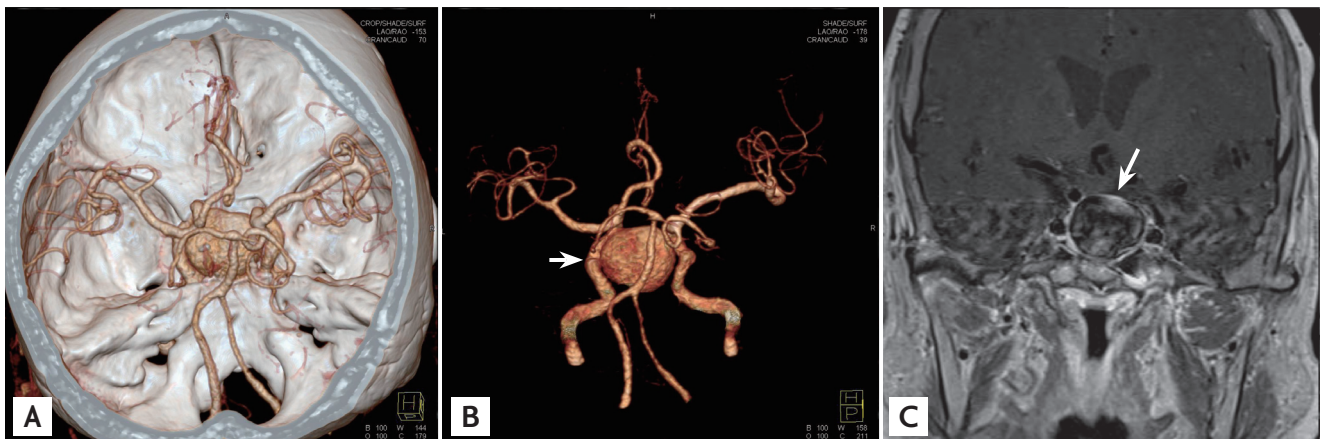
(A, B) Computed tomography angiograph shows the three-dimensional structure of a giant aneurysm arising from the left internal carotid artery (arrow) on the sella turcica. (C) The aneurysm enhanced heterogeneously on T1-weighted magnetic resonance images after injecting gadolinium (arrow).
